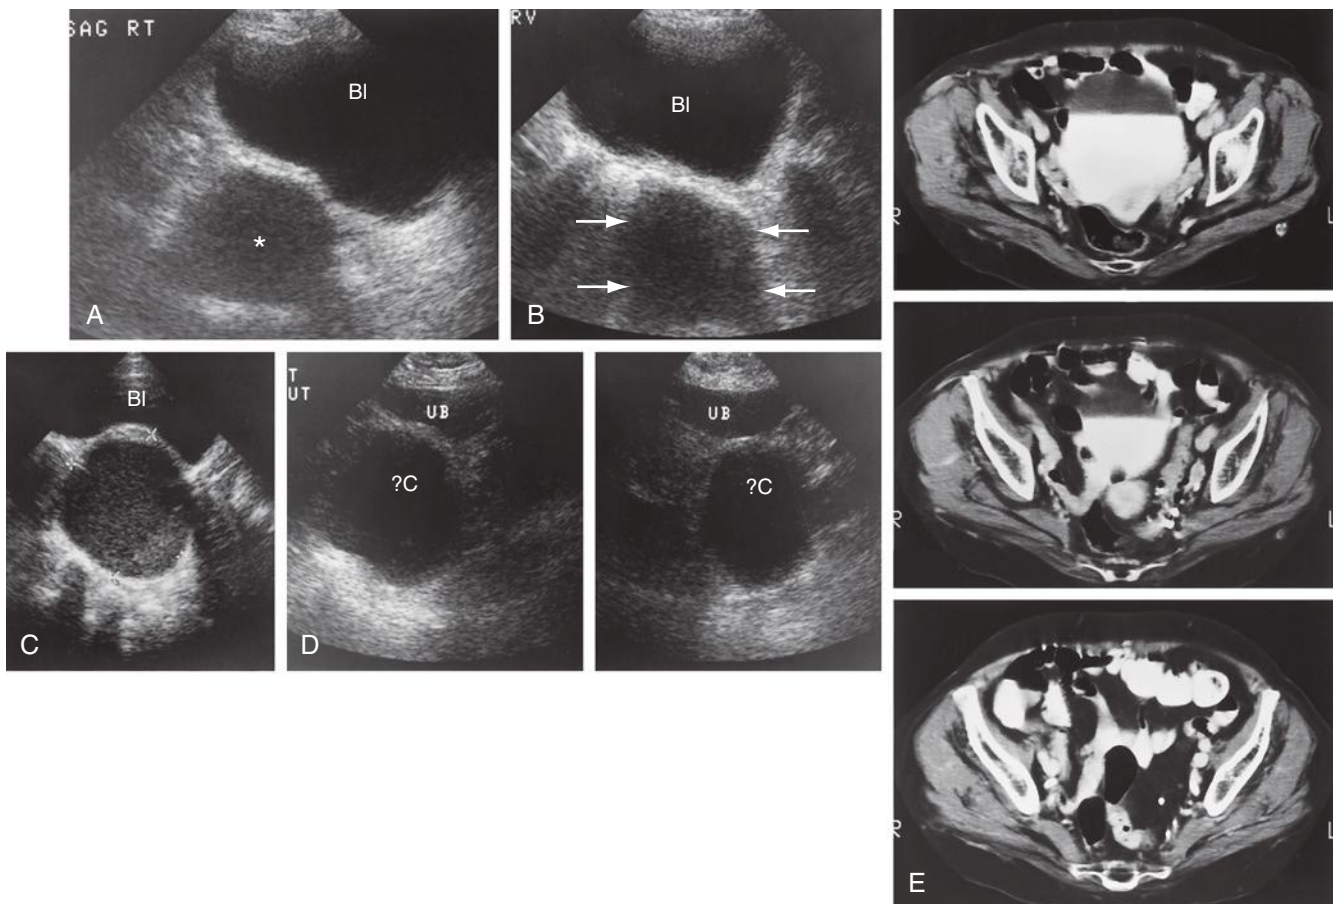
Bowel within the pelvis can masquerade as ovarian cysts. A, In this patient, bowel gas and its shadowing create the appearance of a mass (*asterisk*). BI, bladder. B, The strong reflection adjacent to the urinary bladder (BI) or the "squared" appearance (*arrows*) to the "cyst" should make one suspicious that bowel gas artifact is causing this appearance. C, In a different patient, a true ovarian cyst (*cursors*) has borders on nearly every side and has enhanced through-sound transmission and internal echoes. BI, bladder. D, In another patient, two different planes of section demonstrate what appears to be a large pelvic cyst (?C). In fact, this was due to bowel gas artifact. UB, bladder. E, Because this appearance was virtually indistinguishable from a pelvic cyst, a computed tomographic scan was performed immediately after the sonogram, confirming the artifactual nature of this "cyst." The scans were normal without evidence of a pelvic mass.
